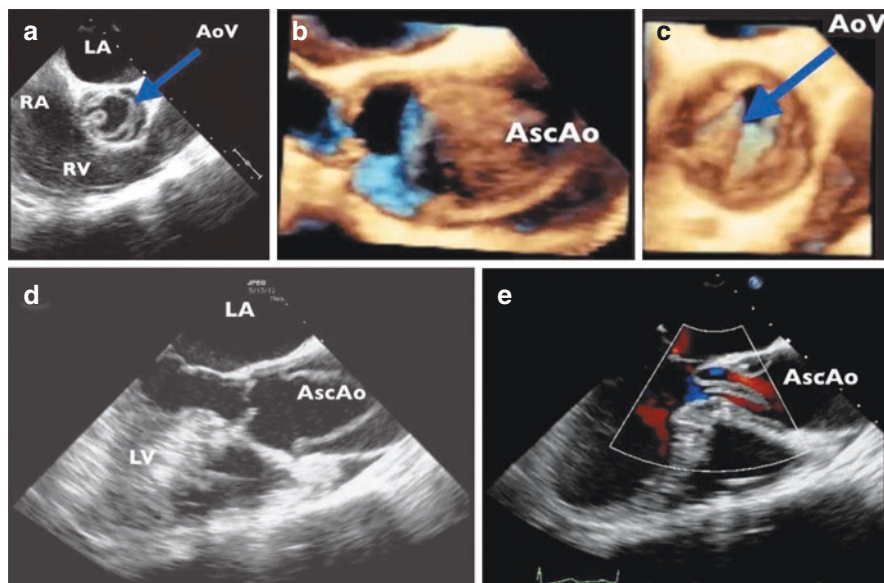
2D and 3D TEE imaging of Aortic Dissection. (a) 2D SAX view of dissection flap prolapsing across the aortic valve (AoV). Surrounding structures: LA-left atrium, RA-right atrium, RV-right ventricle. (b) 3D LAX view of the dissection flap in the ascending aorta (AscAo) (c) 3D SAX view of the dissection flap prolapsing across the trileaflet aortic valve. (d) 2D LAX view of the circumferential dissection flap with insertion at the sinotubular junction. (e) Color Doppler of LAX showing differential flow in large false and small true lumen
